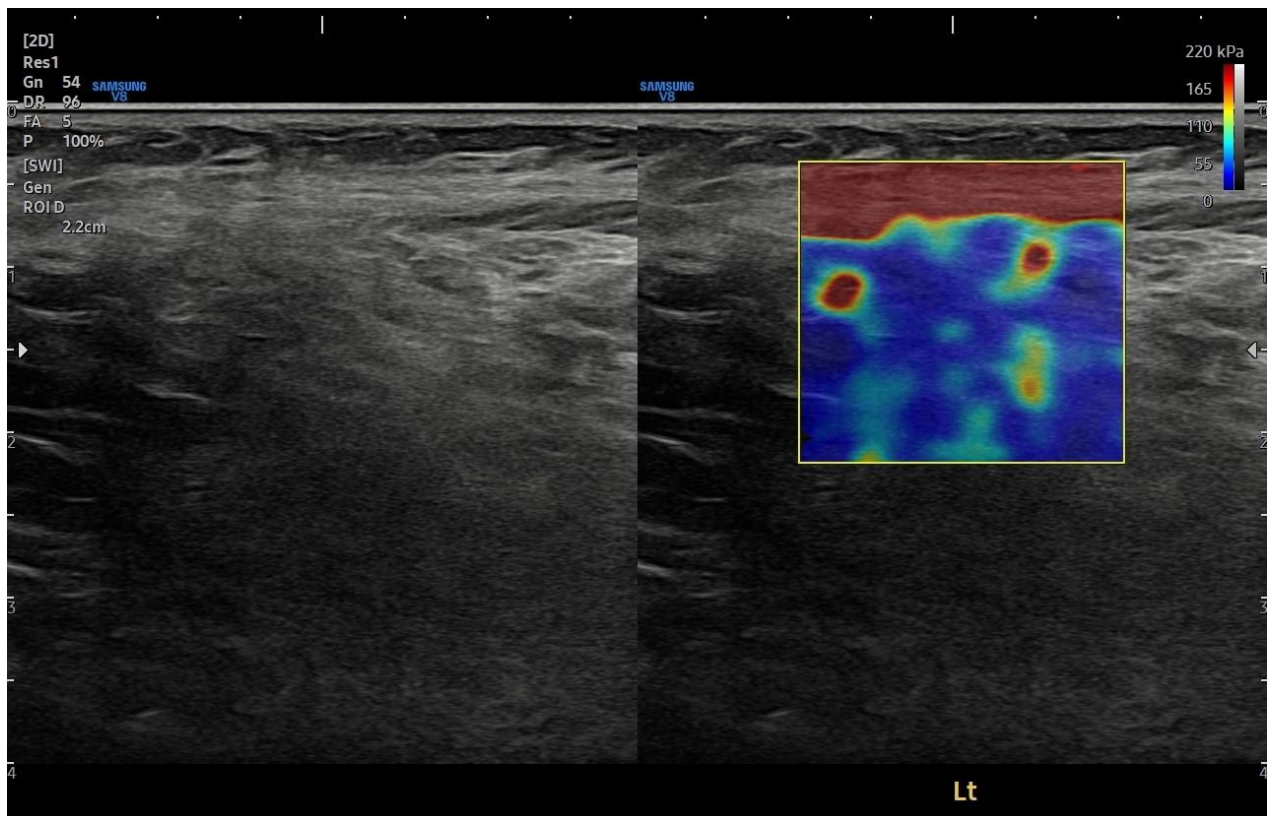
Semiquantitative evaluation of the left iliotibial band stiffness by shear wave elastography. On B-mode ultrasound, no structural changes were visible in the tendon. Increased stiffness in the shear wave was observed in the adhesion areas around the operation site.
